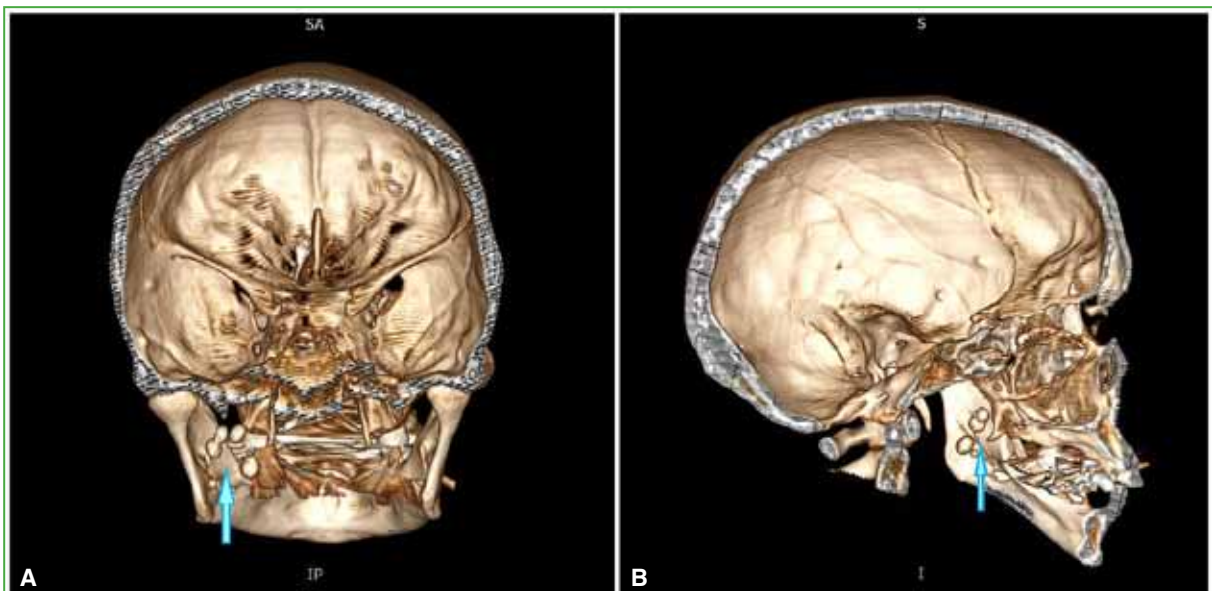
Computed tomography of the craniofacial region. A. Volumetric reconstruction, posterior view. B. Volumetric reconstruction, sagittal view.
